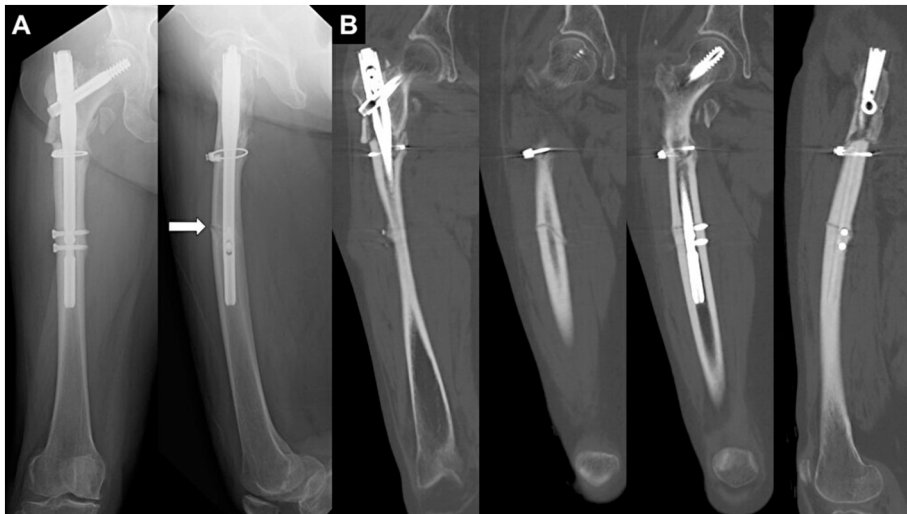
Plain radiographs and computed tomography (CT) images of the right femur 1 year postoperatively. (A) An anteroposterior view of the radiograph shows no abnormal findings. However, a lateral view of the radiograph shows an incomplete fracture line at the anterior part of the distal screw-insertion site (arrow). (B) CT images show a subtrochanteric femoral nonunion and an incomplete fracture at the anterior part of the distal screw-insertion site.
